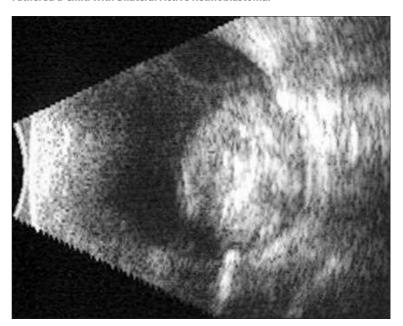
B-Scan Ultrasound Image of Nodular Retinoblastoma Showed Multiple Dense Intralesional Echoes Consistent With Calcific Foci.
